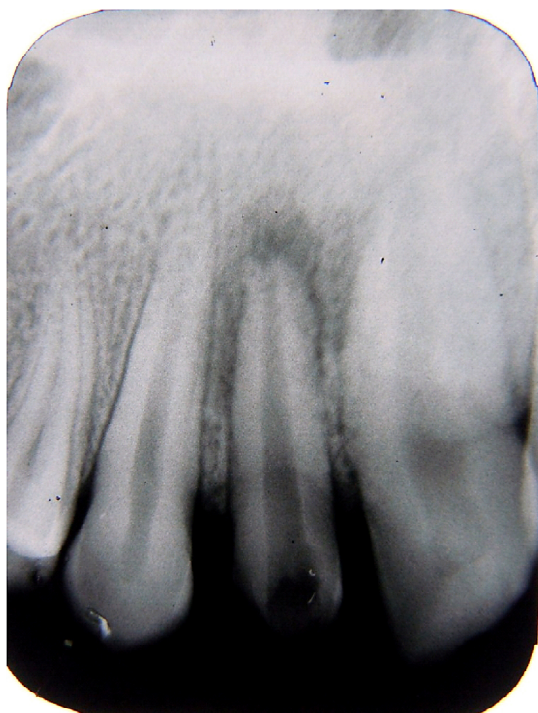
Radiograph of the tooth after the retrieval of foreign bodies.
